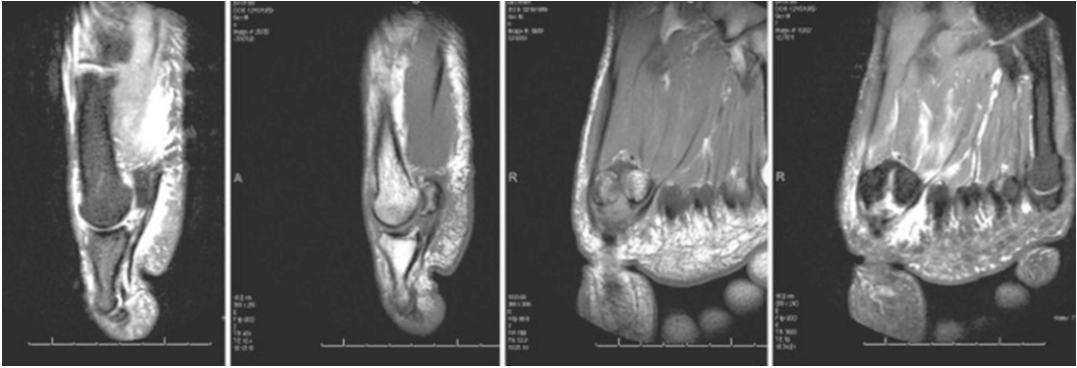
Series of MRI sequences demonstrating disruption of the plantar plate
